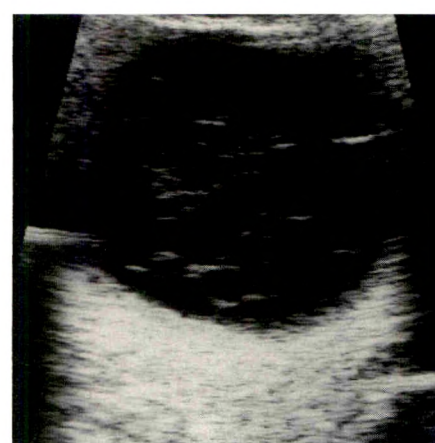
Endophthalmitis. After surgery for cataract extraction, an infection developed in the vitreous of this elderly diabetic patient. Sonogram shows distended globe filled with coarse echoes.
